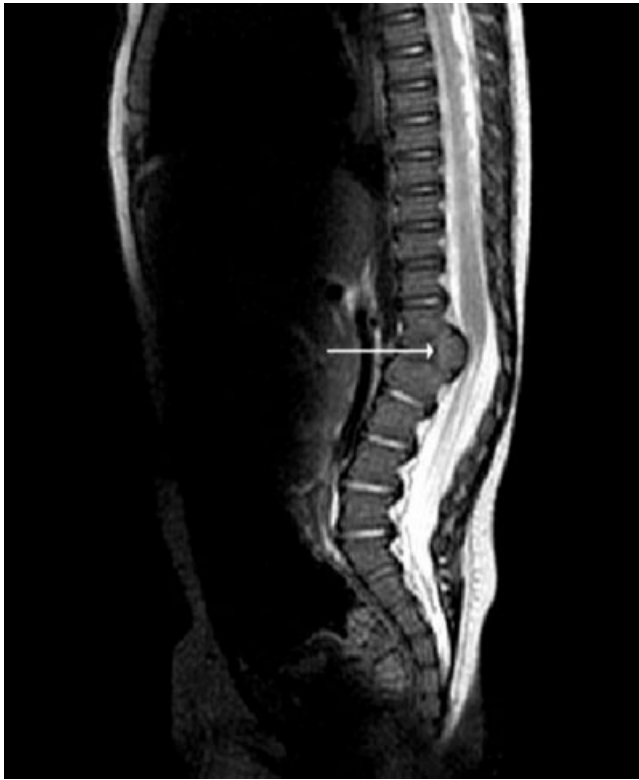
Postnatal magnetic resonance image (sagittal section) of the spine showing a persistent cartilaginous remnant of the posterior part of the vertebral body of L1 (arrow) corresponding to the hypoechoic triangular structure identified prenatally on ultrasound examination.
